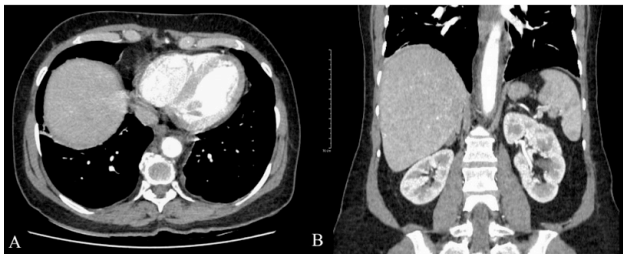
Contrast-enhanced CT scan of the chest and abdomen performed upon hospital admission showing evidence of parietal thickening in the lower third of the descending thoracic aorta, circumferential, measuring up to 0.6 cm in thickness and for an extension of approximately 10.6 cm along the longitudinal axis. A. Axial section. B. Coronal section.
